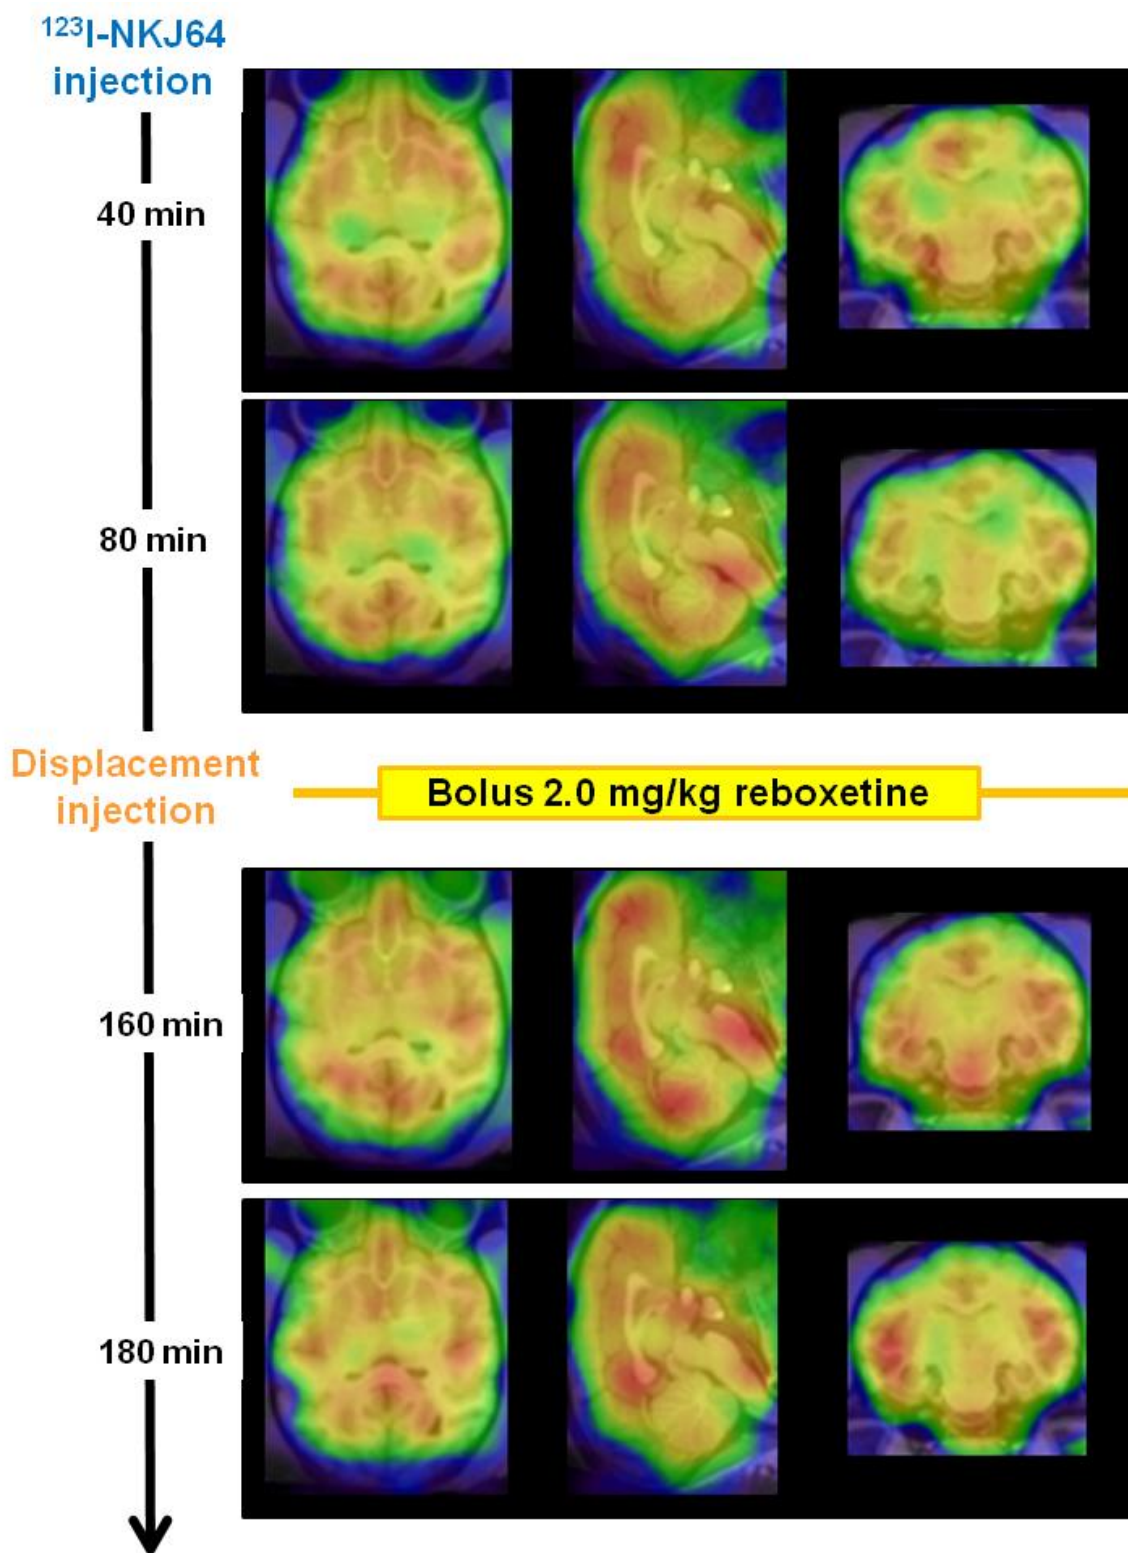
Brain ^{123}I -NKJ64 SPECT images pre- and post-administration of reboxetine in baboon 1.
